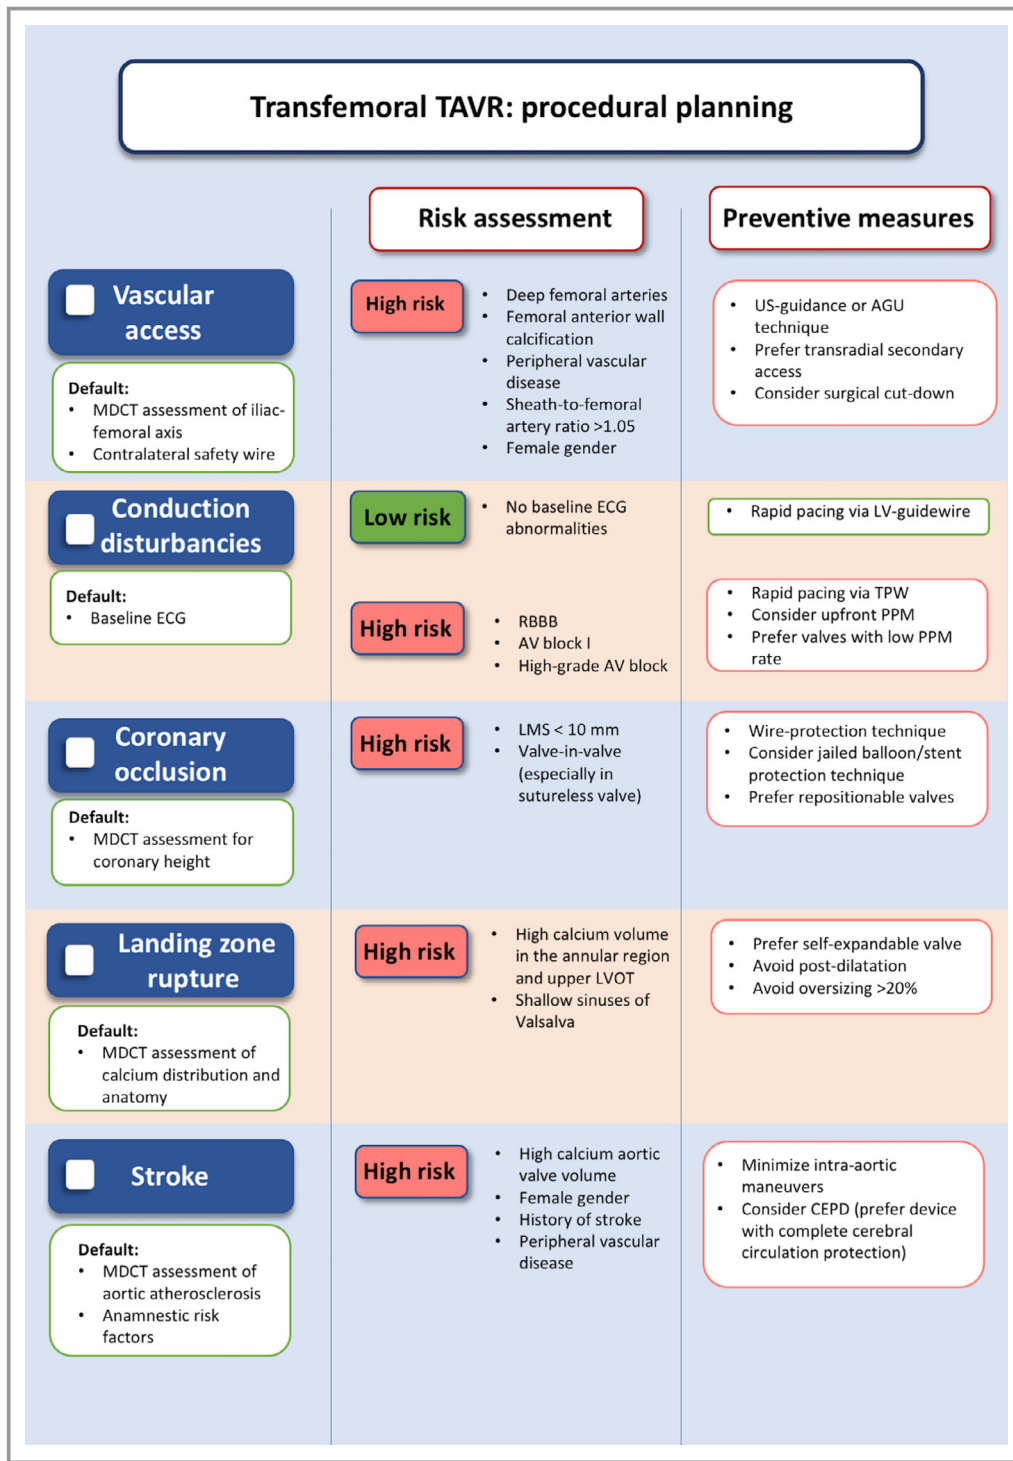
Checklist of avoidable procedural complications as part of the procedural planning for TAVR. AGU indicates angiographic, guidewire, and ultrasound; CEPD, cerebral embolic protection device; LMS, left main stem; LV, left ventricular; LVOT, left ventricular outflow tract; MDCT, multidetector computed tomography; PPM, permanent pacemaker; RBBB, right bundle branch block; TAVR, transcatheter aortic valve replacement; TPW, temporary pacing wire.
